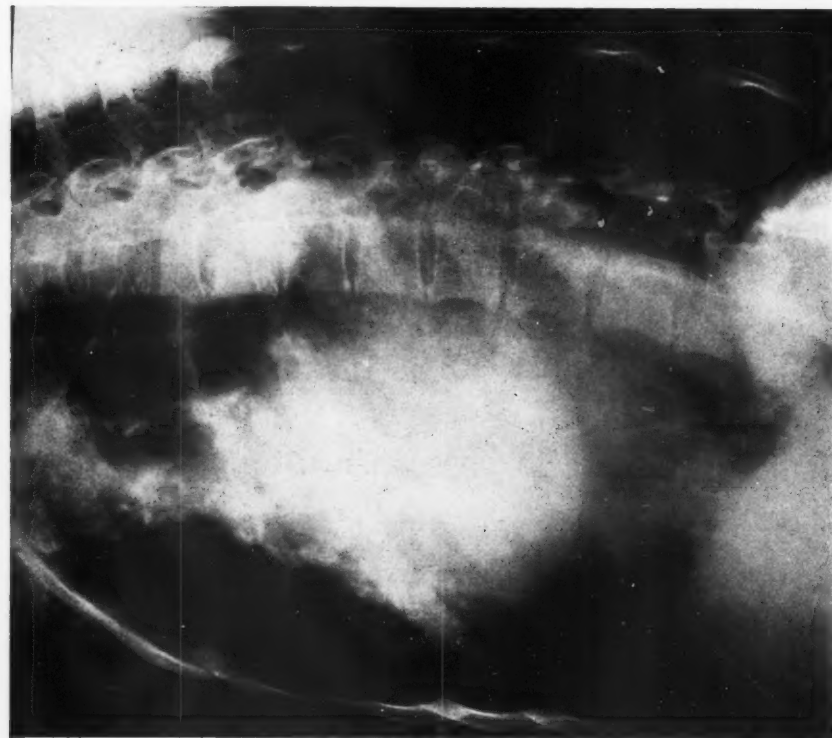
Case 8. High penetration left anterior oblique radiograph for comparison with Fig. 2. There is erosion of the bodies of the seventh, eighth, and ninth thoracic vertebrae. The firm rounded line is breast shadow. Low-penetration films showed that the heart shadow extended much farther downwards and backwards than appears from this radiograph.
